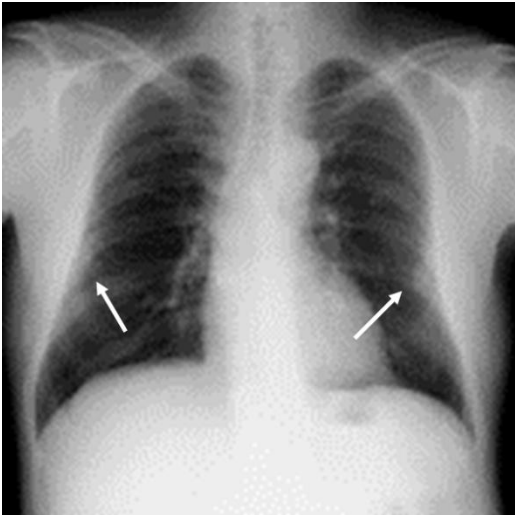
Chest roentgenogram showing noncalcified pleural plaque that is symmetrical to both chest walls (arrow).
